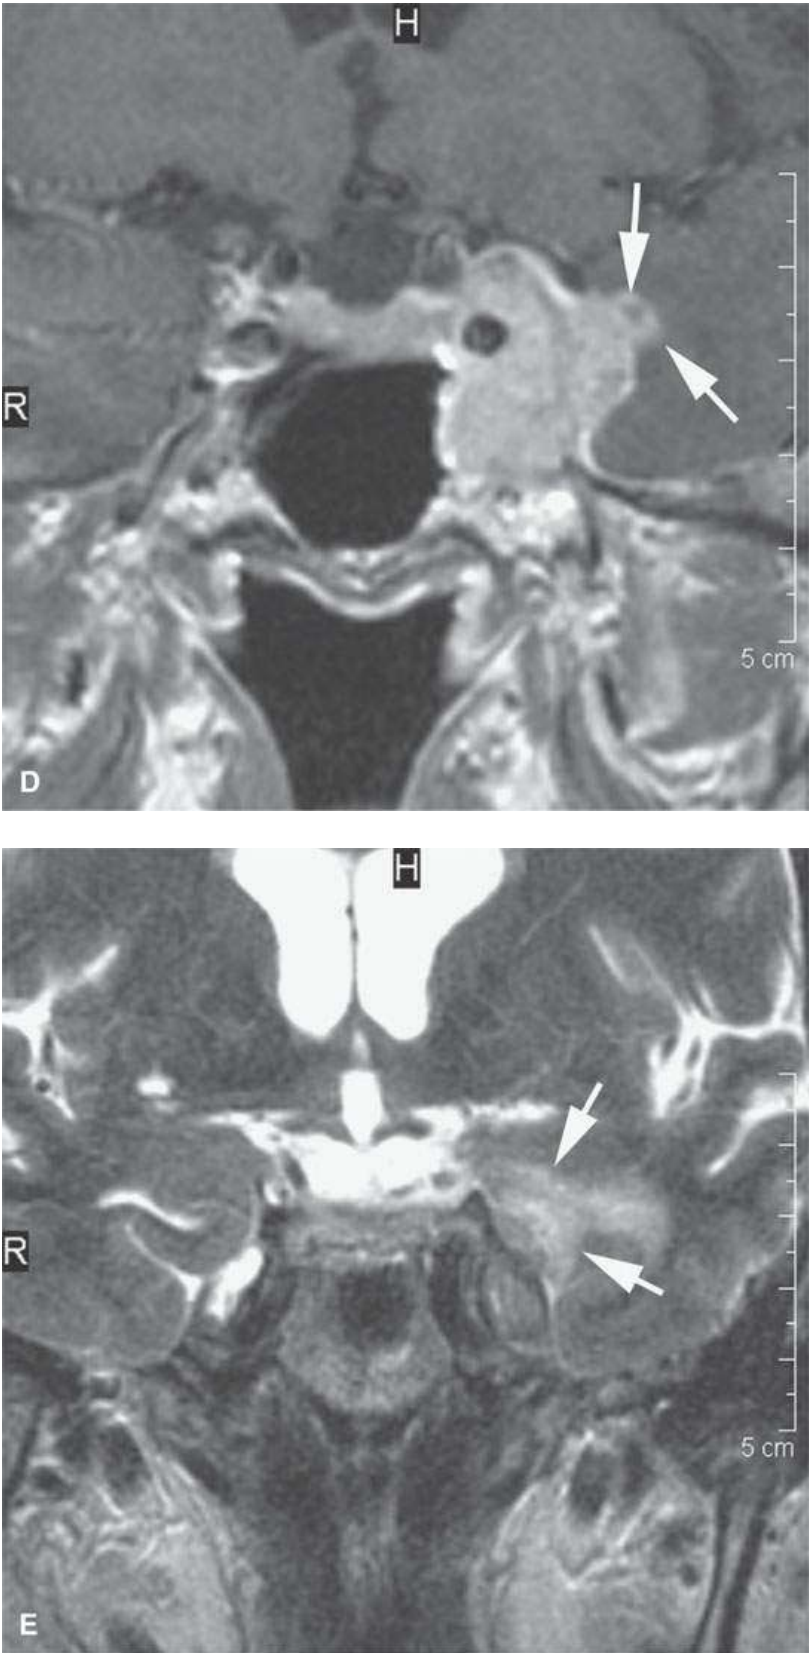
Magnetic resonance imaging of a patient with perineural spread of forehead squamous cell carcinoma along the first division of the trigeminal nerve to the trigeminal ganglion from which it invades adjacent brain Findings are indicated by *arrows* in each figure. A–D: Contrast-enhanced T1-weighted images show the typical location of such spread superior and medial in the orbit along the supratrochlear and supraorbital neurovascular bundles (A), disease at the orbital apex (B) and to the trigeminal ganglion and cistern (C, D), where it invades across the lateral dura of the cavernous sinus to invade the brain. E: The brain involvement is confirmed by the T2-weighted image showing brain edema.
